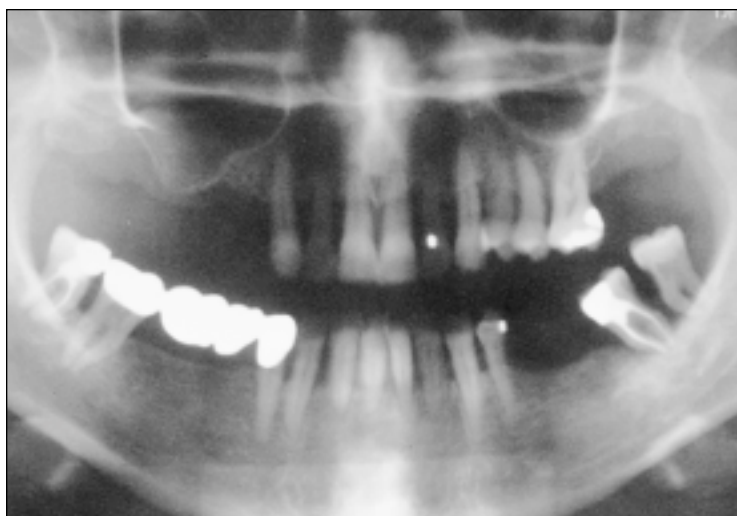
Preoperative orthopantomograph. Note the great pneumatization of the right maxillary sinus and the minimal subsinusual osseous thickness of 2 mm.
